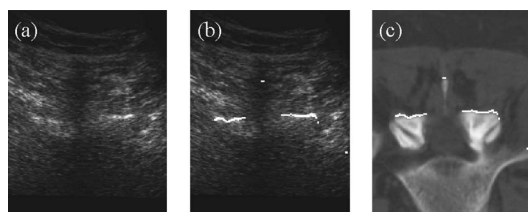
(a) Intraoperative axial ultrasound image of a vertebra. (b) Bone surface at the registered position. (c) Corresponding CT image.
